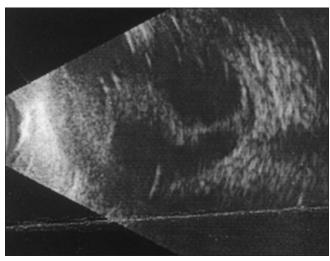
B scan ultrasonography of the right eye showing phthisis bulbi
